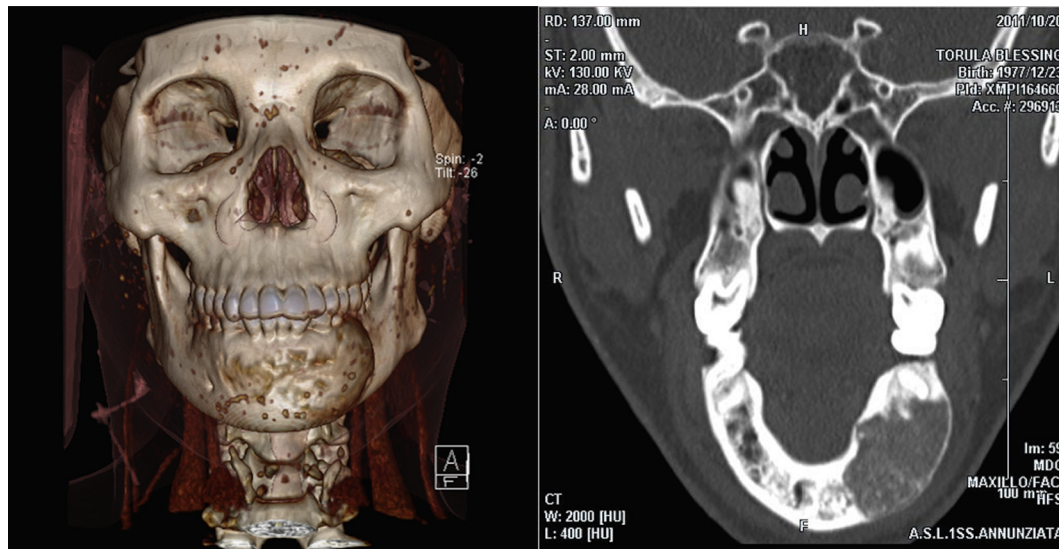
Computed tomogram before tumour ablation (aggressive osteoblastoma).
